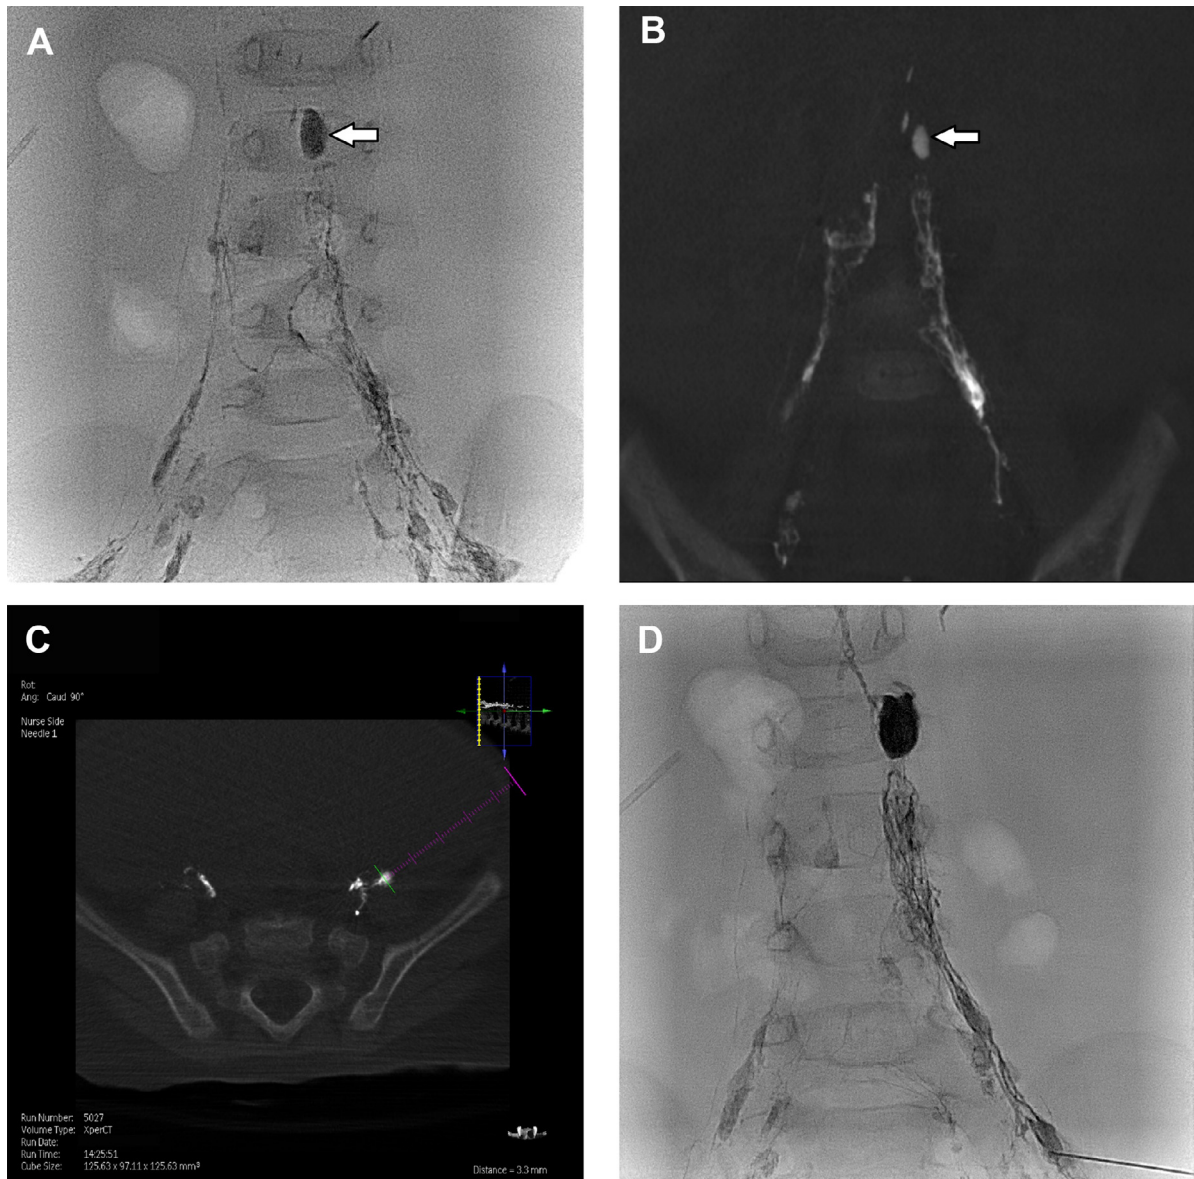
Frontal fluoroscopic image following bilateral inguinal access and lymphangiography using ethiodized oil (A) demonstrated a single focus of lymphatic extravasation in the left retroperitoneum (arrow). Cone beam CT was performed (C), confirming the focus of extravasation (arrow) and further characterizing retroperitoneal lymphatic anatomy. A left lateral external iliac chain node was identified and targeted using cone beam CT guidance with navigational overlay (XperGuide, Philips) (C). Following contrast confirmation of inline drainage to the focus of extravasation, embolization was performed using cyanoacrylate (D) with preservation of the right-sided lymphatics.
